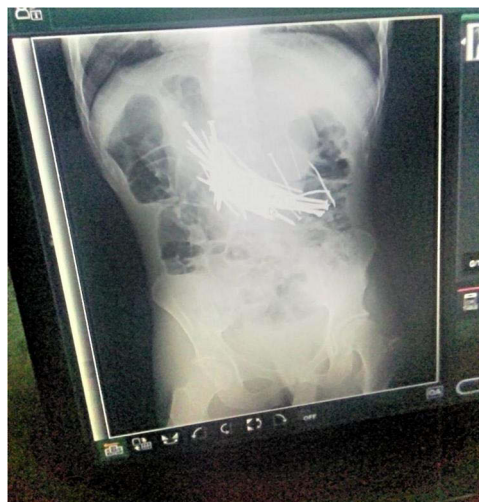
Plain abdominal x-ray showing multiple metallic nails in the stomach and first part of the duodenum.
